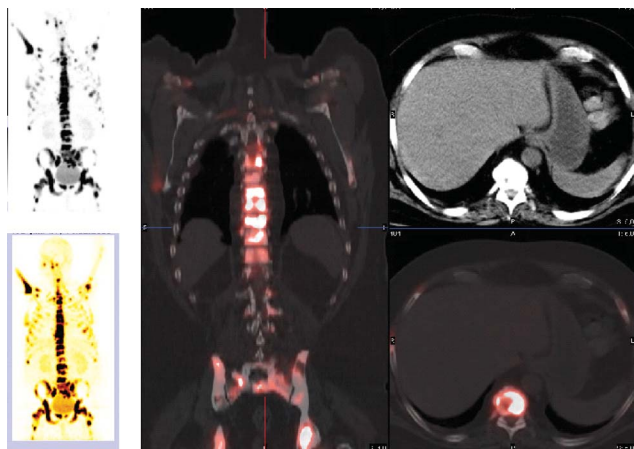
^{68}Ga -BPAMD PET, CT and PET/CT for imaging of bone metastases (first in human use) in a patient with prostate cancer.³⁷
